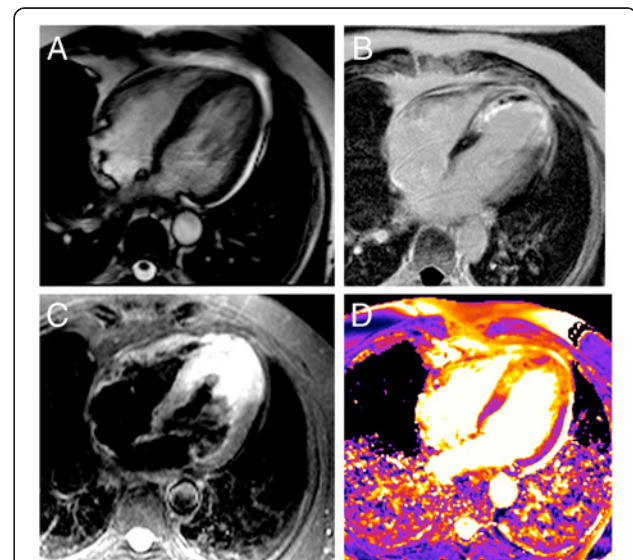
T2-mapping in acute apical infarction. The diastolic cine frame (A) reveals apical septal wall thickening in the area of edema. Late gadolinium enhancement shows apical infarction scar with microvascular obstruction (B). While conventional T2-weighted STIR image depicts both, edema and bright slow flowing blood within the lumen (C), T2 map correctly indicates edema color-coded in orange with an apical T2 of 91 ms (D). The microvascular obstruction corresponds to a T2 of 60 ms, color-coded in pink. Basal T2 was 54 ms.
